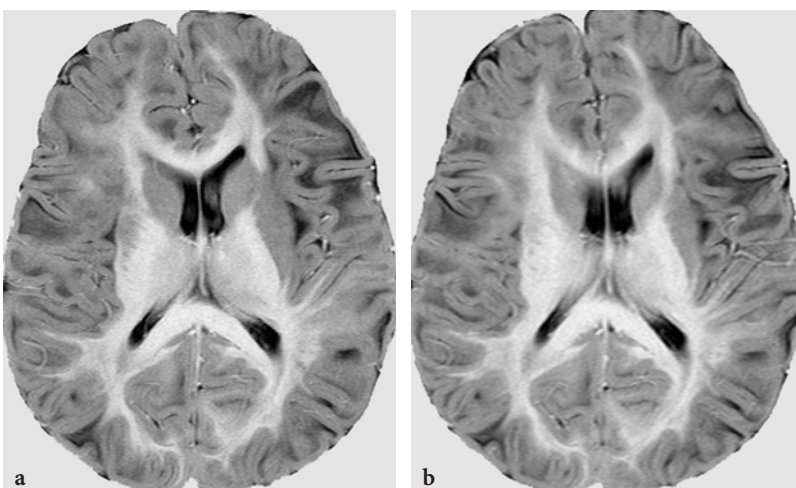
Follow-up MR studies in a male patient with L-2-hydroxyglutaric aciduria. a Axial T1-weighted inversion recovery image at the age of 12 years, showing the typical centripetal demyelination pattern of the disease. b Axial T1-weighted inversion recovery image 2 years later, showing an unchanged, stable appearance of the demyelinating process
